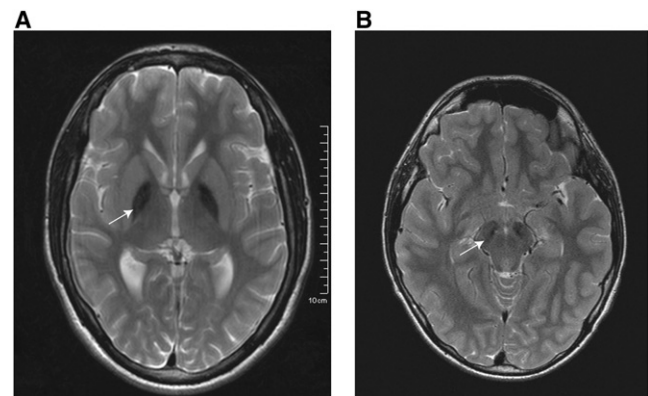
Magnetic Resonance Images of Cases with the Homozygous C19orf12 Deletion c.204_214del11, p.Gly69ArgfsX10 Axial T2-weighted magnetic resonance imaging (1.5 T) shows a bilateral hypointensity of the globus pallidus (A) and substantia nigra (B).
